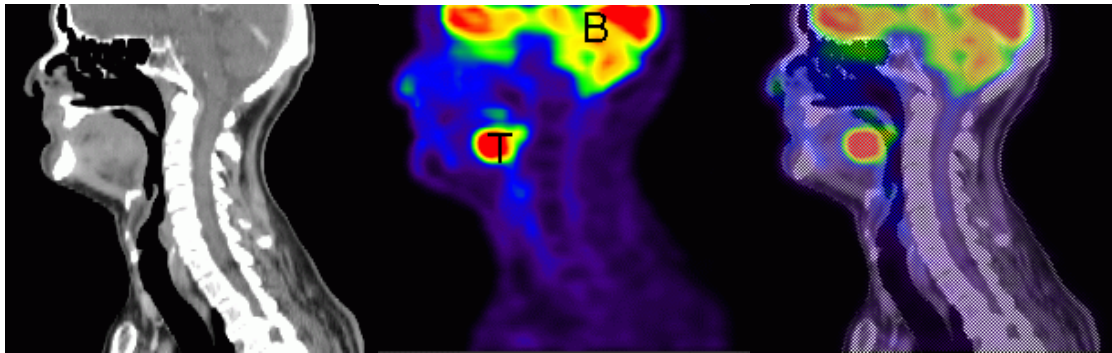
Clinical FDG-PET/CT investigation of the head and neck region: CT (left), PET (middle) and fused (right) sagittal images. B: normal FDG uptake in the brain; T: FDG uptake in the tumor in the base of tongue.
